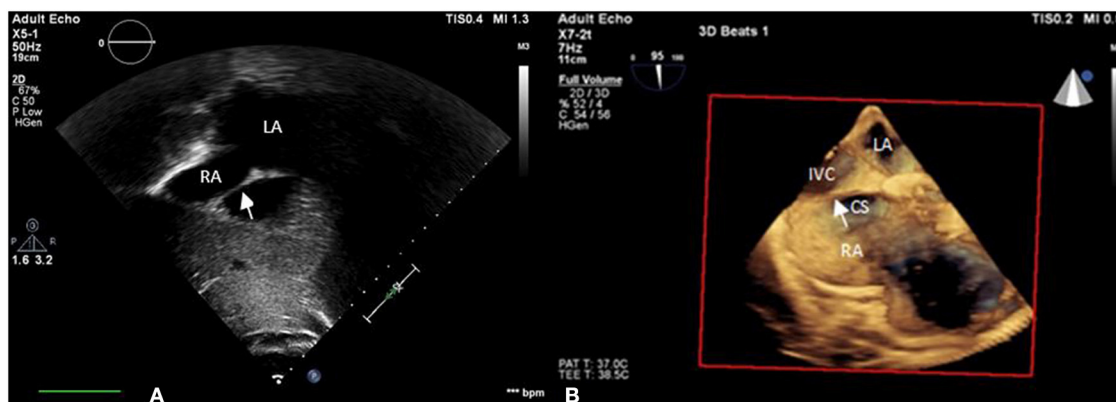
iCTD (arrow) at the connection of the right atrium and inferior vena cava is shown in (A) transthoracic echocardiogram (TTE) and (B) three-dimensional TEE. LA, left atrium; RA, right atrium; CS, coronary sinus; IVC, inferior vena cava.
